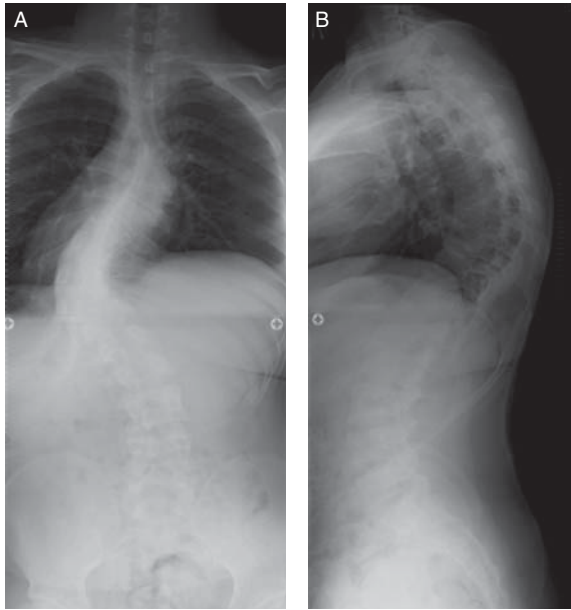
Preoperative plain radiographs show a left convex coronal curve of  $86^\circ$  from T8 to T12 (A) and thoracic kyphosis of  $67^\circ$  from T5 to T12 (B).
